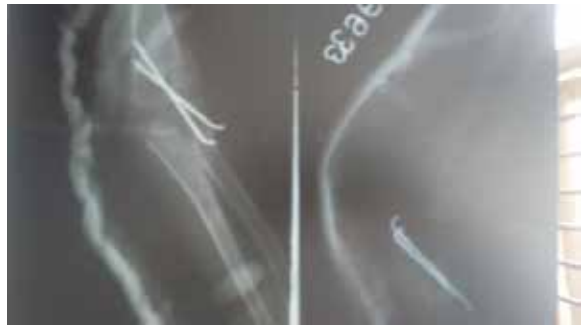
check x-ray at 1 week follow up
